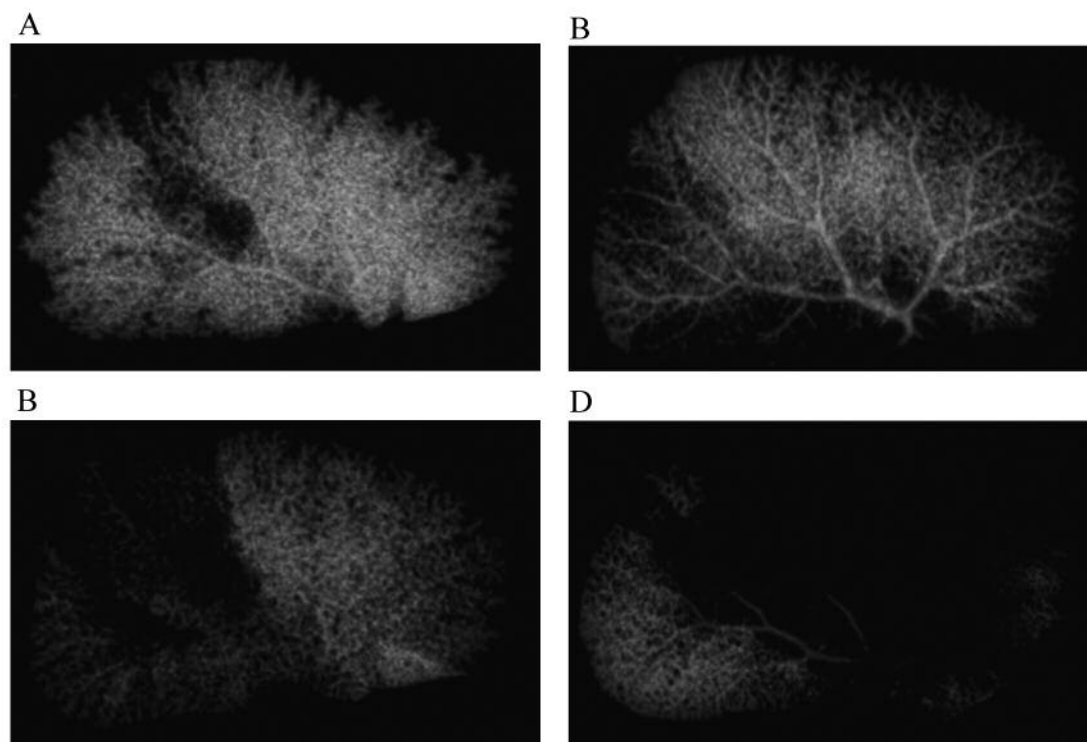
Comparison of blood vessel damages induced by miriplatin (MPT) and epirubicin (EPI). Drug was administered into the portal vein. A: soybean oil, B: (1 mg) MPT suspended in soybean oil, C: 0.1 mg of EPI and soybean oil, D: 0.5 mg of EPI and soybean oil. Two days later, 0.2 ml of barium sulfate was administered into the portal vein. X-ray CT imaging of the liver leaf was performed.
